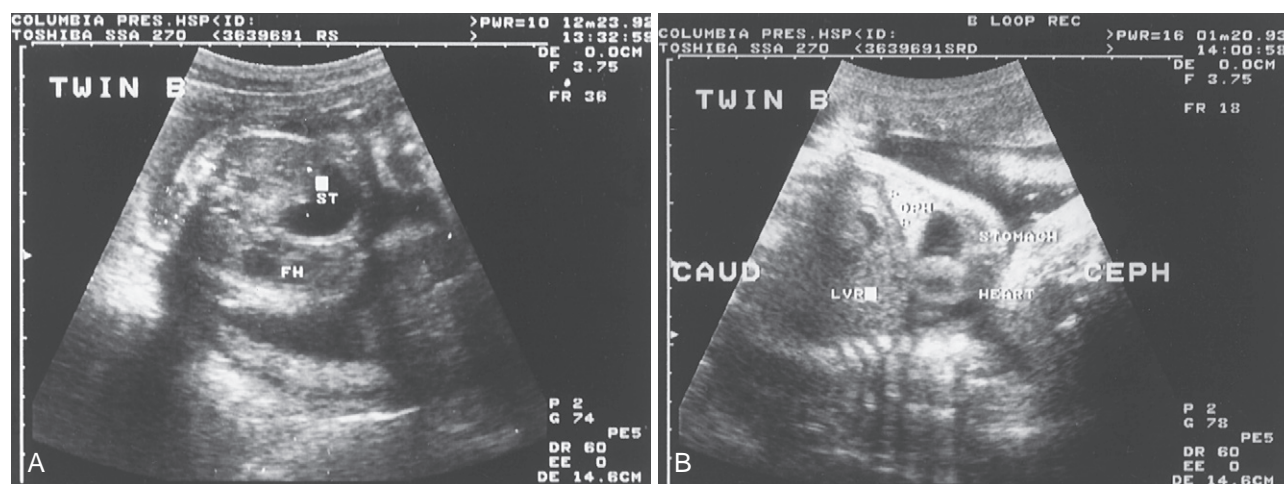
A, Ultrasound examination of a 28-week gestation fetus (twin B) in cross section demonstrating the fetal heart (FH) and stomach (ST) in the same plane. B, Ultrasound examination of the same fetus but in a sagittal plane, demonstrating relationship of the stomach, liver, and heart.
